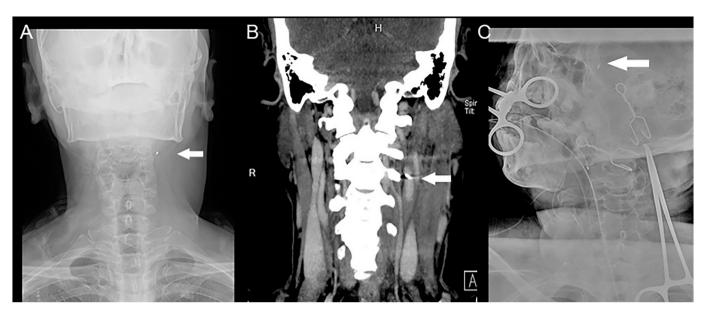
(A) Anterior-posterior neck X-ray and (B) coronal view of computer tomography (CT) angiography demonstrated a radiopaque lesion located in the carotid region (arrow). (C) Post operation skull and neck X-ray showed the radiopaque lesion located in the intracranial region (arrow).
